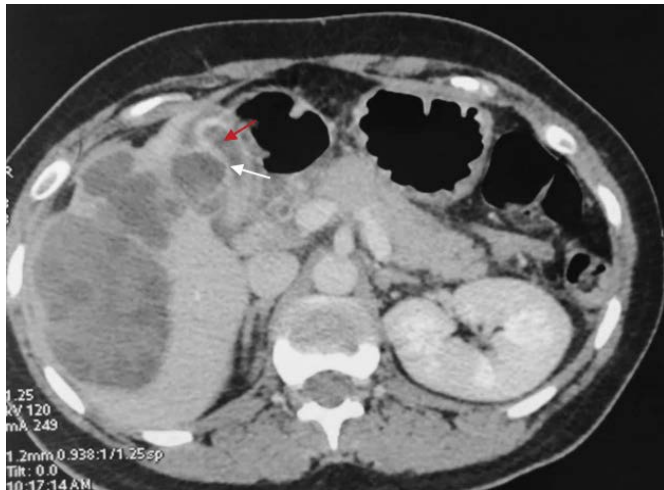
Coronal abdominal CT-scan picture showing a multi-located hepatic cyst lesion with many endogenous daughter cysts and exogenous daughter cysts adhering to the gallbladder (white arrow). Presence of daughter cysts in the gallbladder lumen (red arrow).
